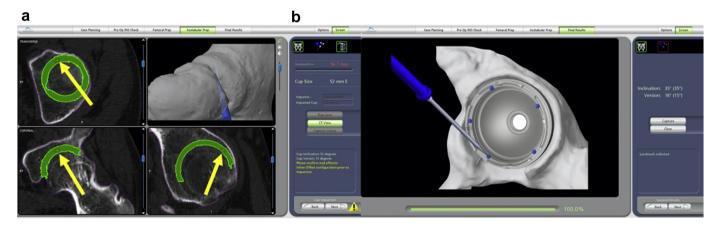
Verification of the cup position using hip probe avoids the need for fluoroscopy. (a) The hip probe is used to verify the actual cup position with respect to preoperative CT plans on all 3 planes. (b) Surgical results of the cup plane view to verify the cup inclination and anteversion by registering 5 points along the rim.
